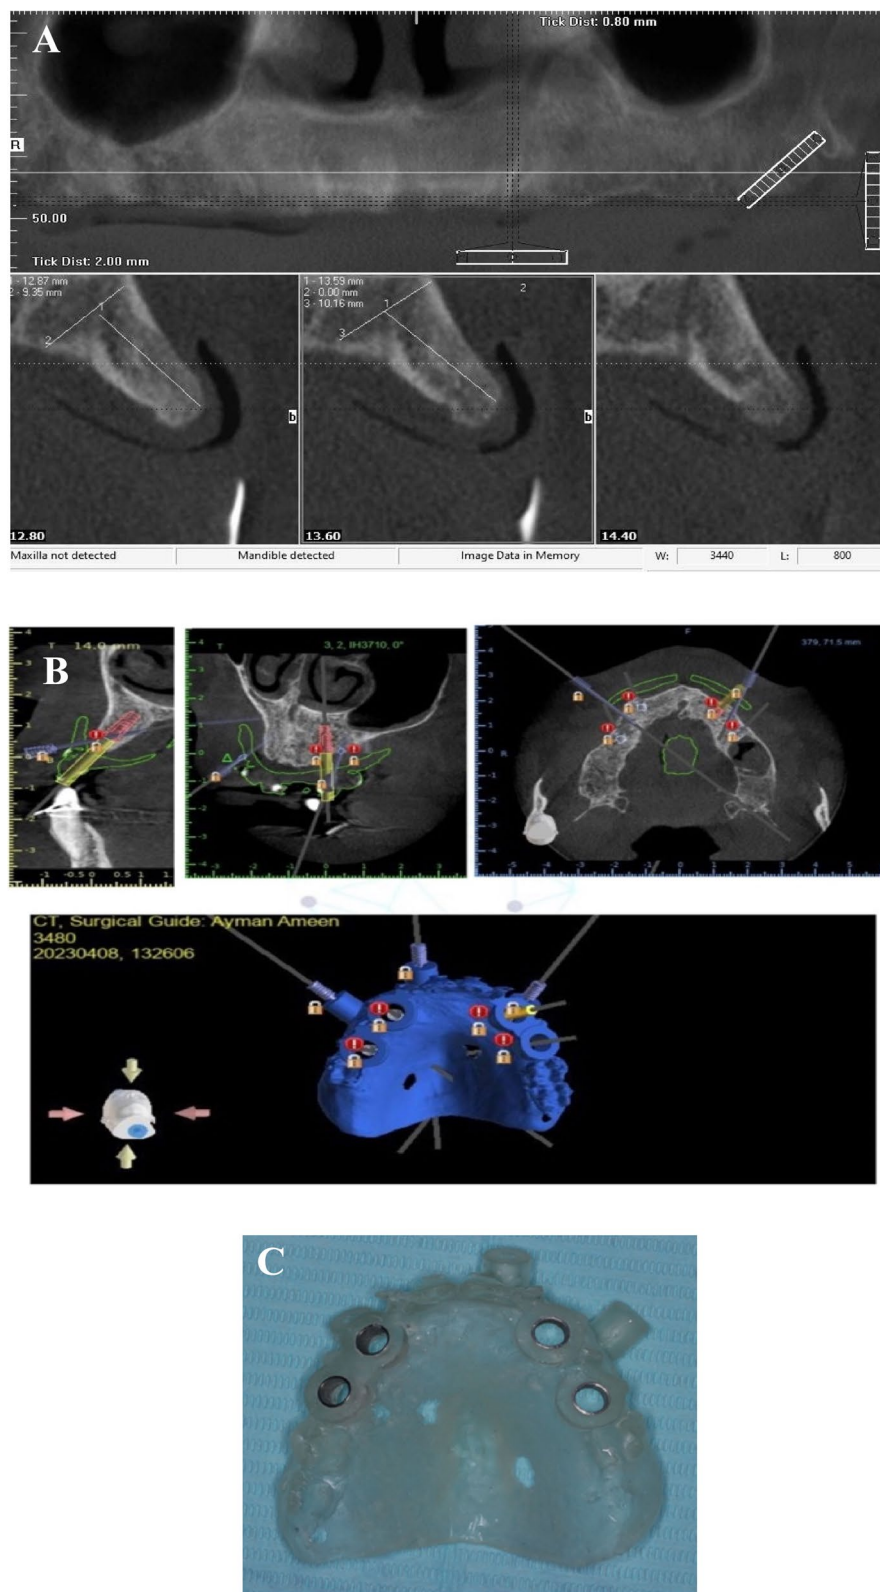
A CBCT of patient with the maxillary denture, B Digital implant planning and guide designing, C Printed Guide from clear acrylic resin
